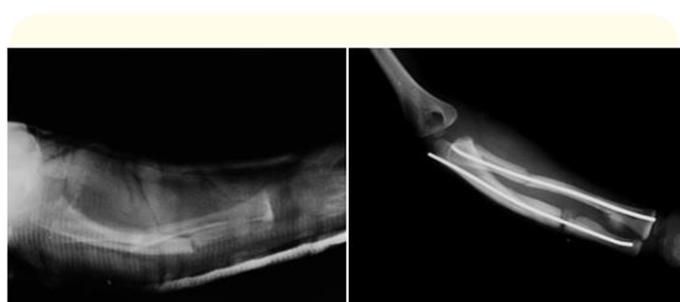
Radiography of the forearm showing diaphyseal fractures of radio and ulna and subsequent osteosynthesis with flexible intramedullary nail. Visualize the formation of ossification of the interosseal membrane in the postoperative.
